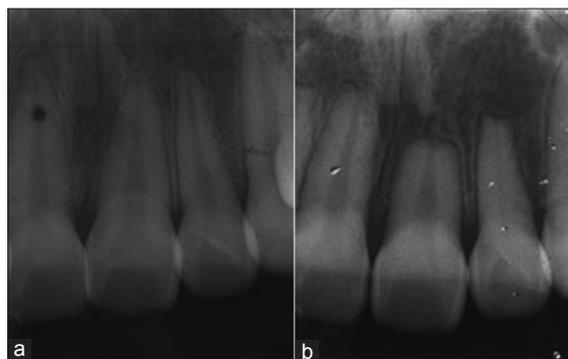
(a) Radiograph of the tooth before orthodontic treatment (b) radiograph of tooth showing ARR after orthodontic treatment
